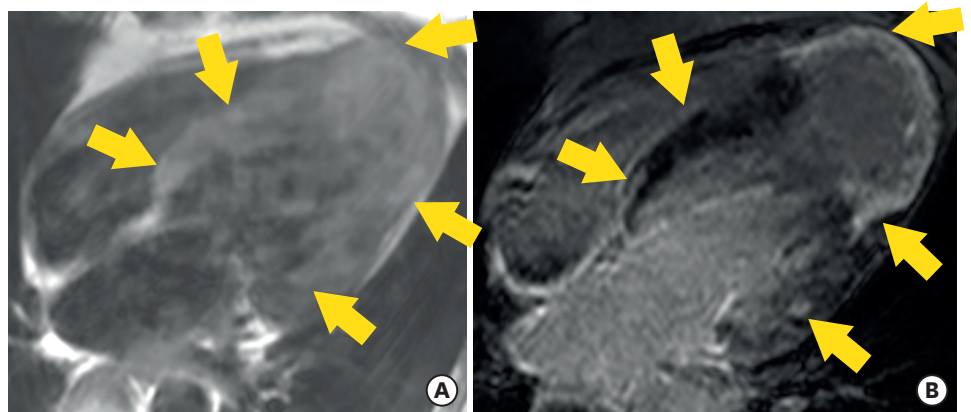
Cardiac MRI image. (A) T2WI and (B) LGE image. There are multiple focal LGEs in left ventricle (B) where T2WI also shows pale high intensity with unclear margin. It suggests active inflammation. LGE = late gadolinium enhancement; MRI = magnetic resonance imaging; T2WI = T2 star weighted image.
